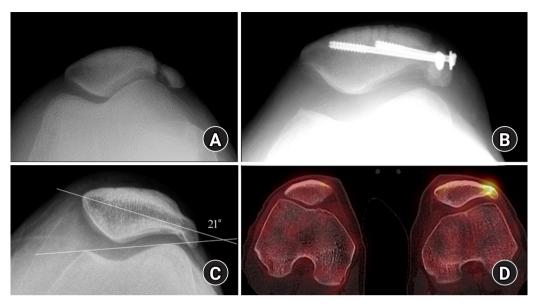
A 41-year-old male patient. (A) Lateral marginal fracture of the left patella. (B) Displaced fragment after screw fixation. (C) Skyline view showing malunion of the lateral patella and 21° lateral tilt. (D) Bone single-photon emission computed tomography revealing hot uptake at the lateral fragment.
